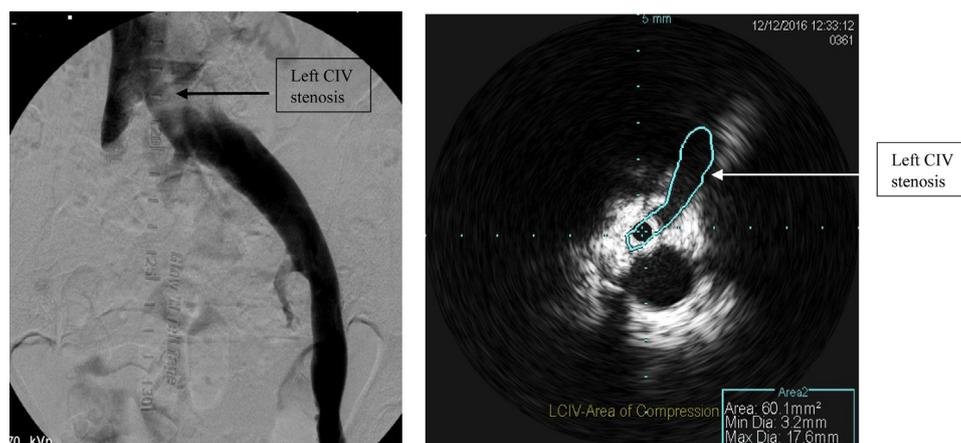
Venogram and intravascular ultrasound (IVUS) demonstrating an uncompensated left common iliac vein (CIV) stenosis in a woman with pelvic pain.
